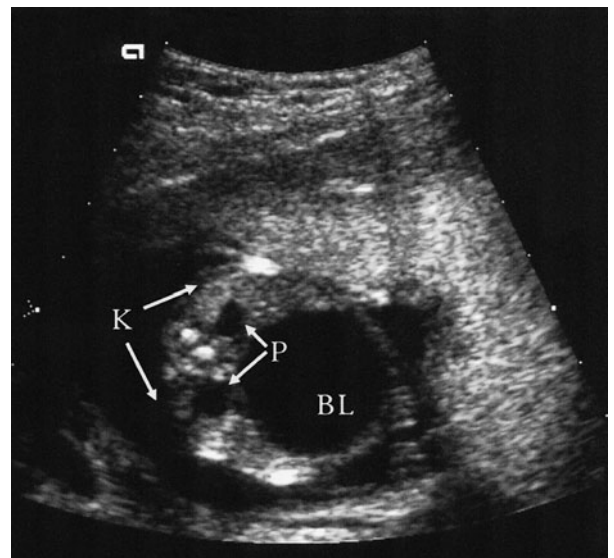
Ultrasound of hydronephrosis showing enlarged bladder (BL), compressed renal parenchyma (K), and dilated renal pelvises (P).
